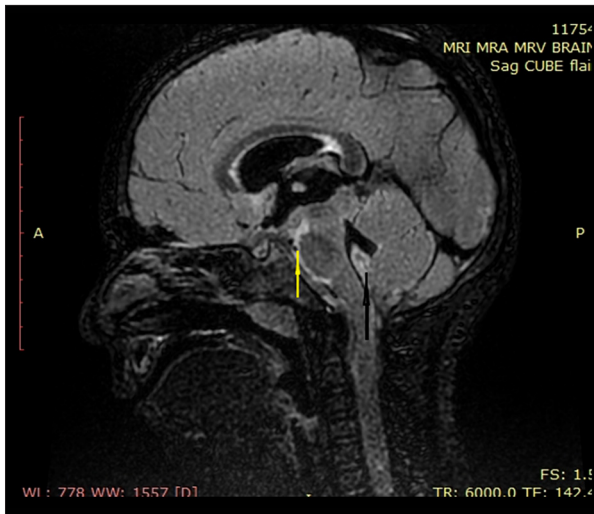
Sagittal MRI scan, CUBE FLAIR sequence, depicting blood within the fourth ventricle and in the basal cisterns anterior to the brain stem. MRI – magnetic resonance imaging; FLAIR – fluid-attenuated inversion recovery; CUBE FLAIR – the General Electric (GE) name of their sequence and not an acronym.
